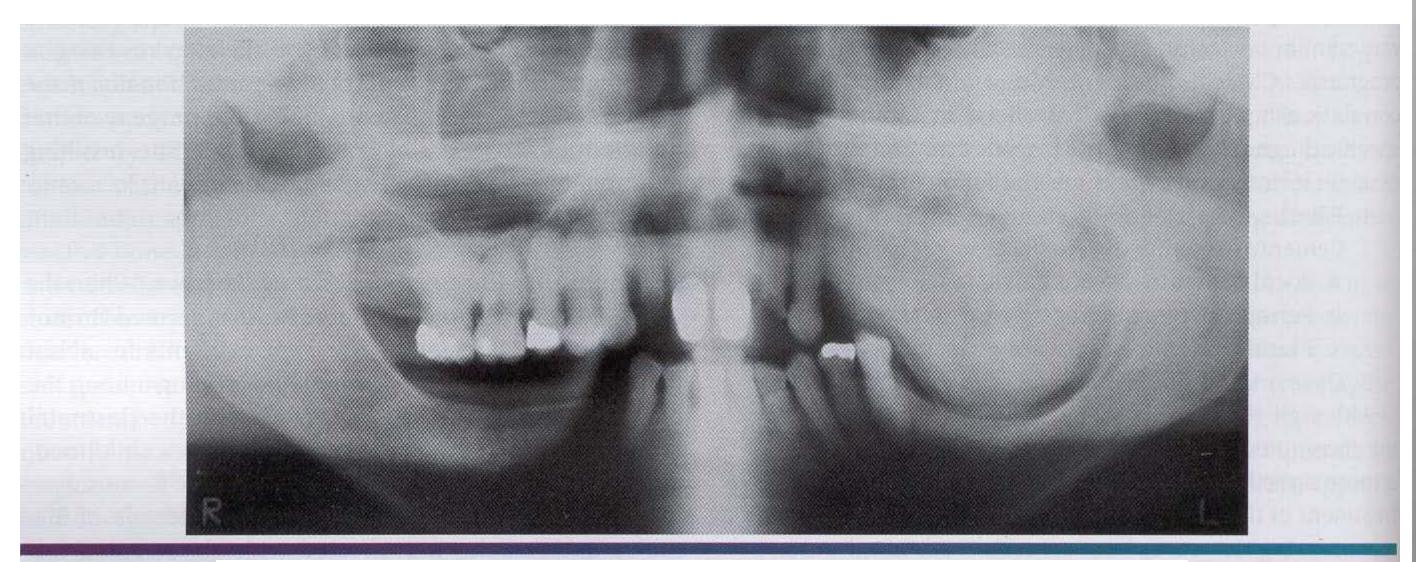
• Fibrous dysplasia. Panoramic radiograph of the patient shown in Figure 14-31. A diffuse "ground-glass" radiopacity is evident. (Courtesy of Dr. Richard Brock.)
